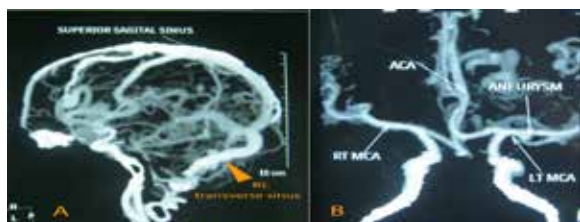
CT Angio of brain showing dilated vessels in venous (A) and arterial (B) phases.
